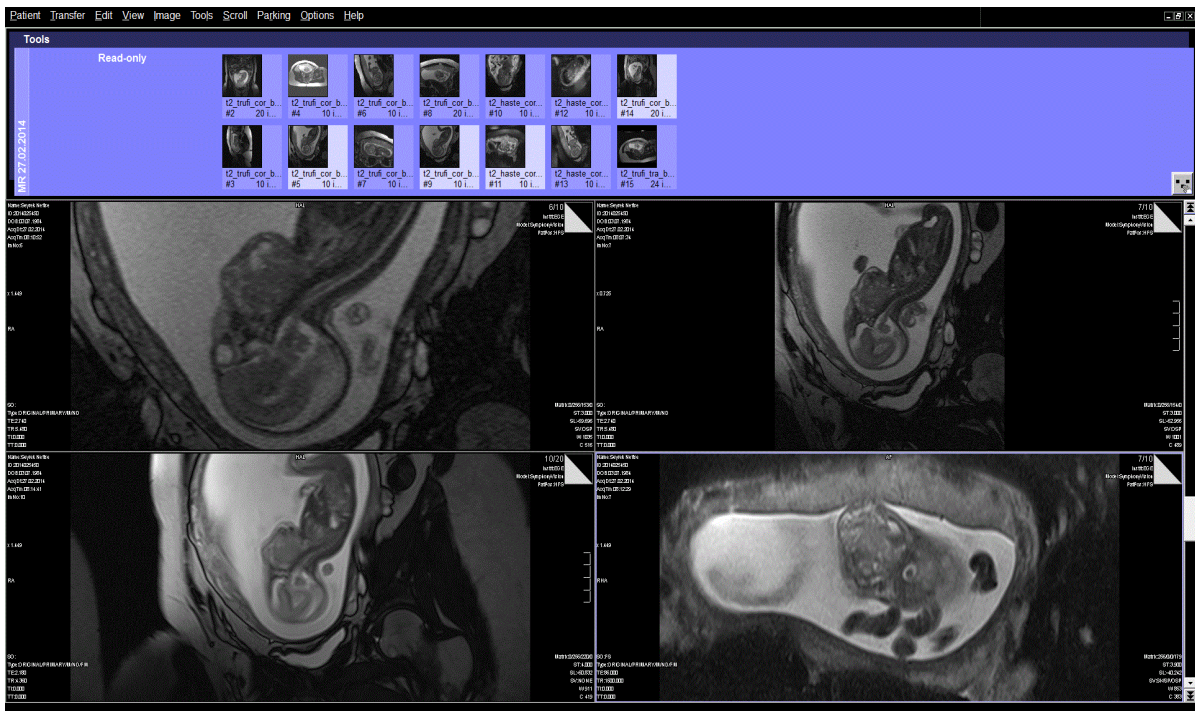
Intrauterin fetal MRI.
